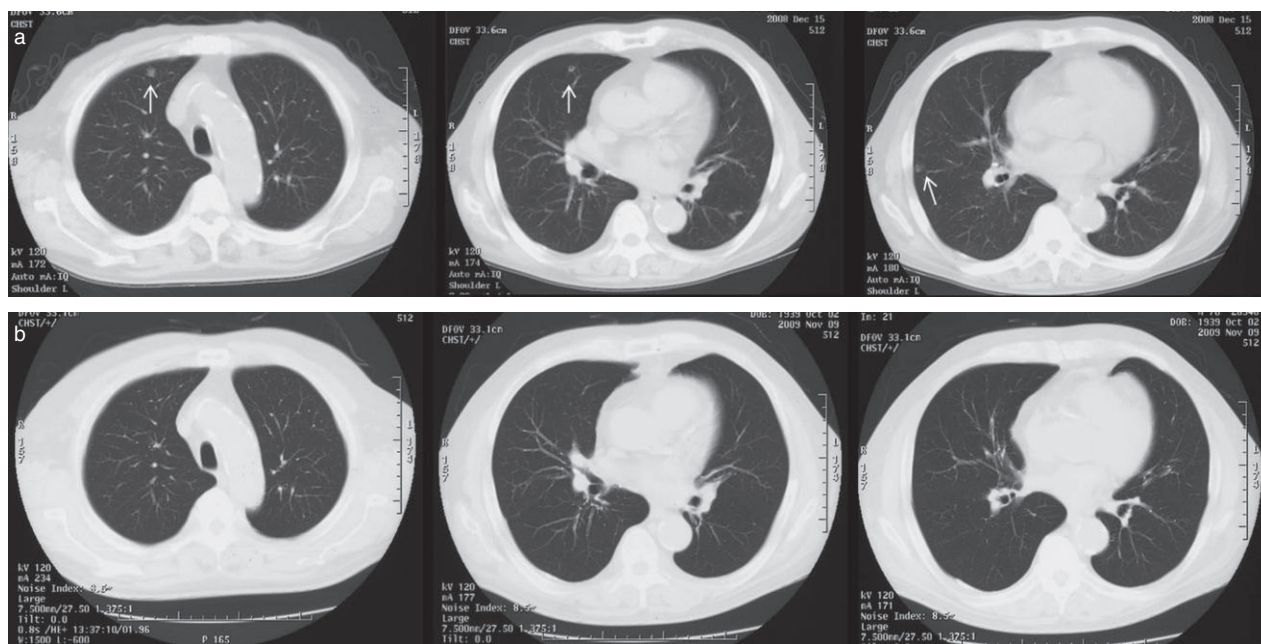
(a) Chest computed tomography (CT) showing multiple pulmonary nodules (arrows). (b) One year after the start of anti-androgen therapy, the pulmonary nodules have disappeared.
